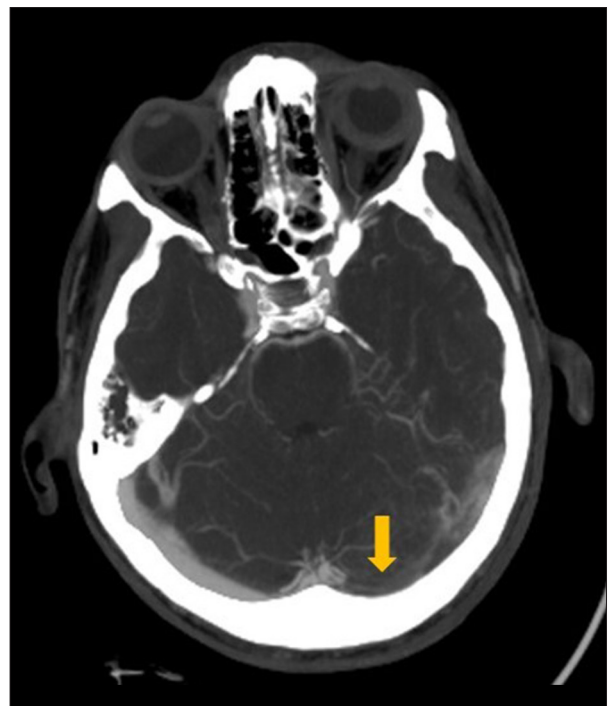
Computed tomography venography of the brain revealed an absence of flow at the level of the left transverse sinus, while showing preserved flow on the right transverse sinus.
